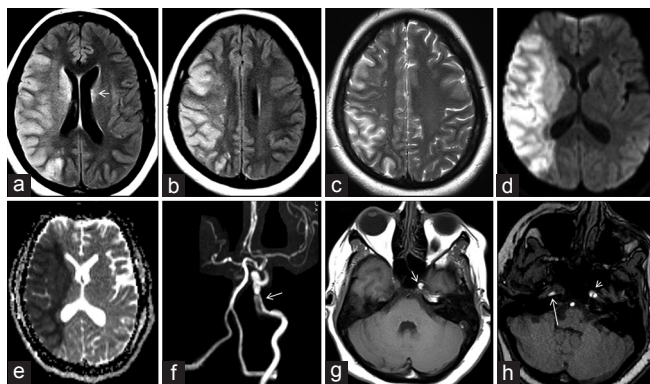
MRI after stroke onset. (a, b) Axial FLAIR and (c) Axial T2-weighted MRI showing residual left caudate nucleus hyperintensity (arrow) and resolution of rest of the previously noted abnormalities. (d) DWI and (e) ADC images showing a large right MCA territory acute infarct. (f) TOF MR angiogram showing occlusion of the right ICA and MCA, and the dissection flap in the left petrous ICA (arrow). (g) Axial T1-weighted image showing a hyperintense blood signal in the left petrous ICA wall (arrow). (h) Source images of TOF MRA showing the hyperintense intramural blood in the right petrous ICA wall (long arrow), and a double lumen in the left petrous ICA (short arrow)
